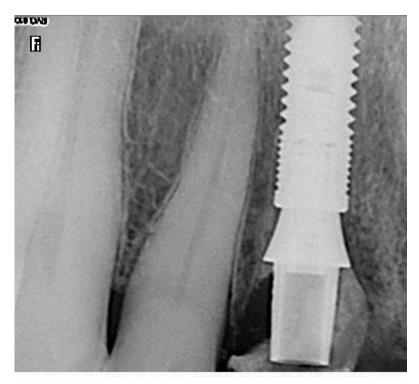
Post-op intra-oral x-ray after #11 implant placement.
